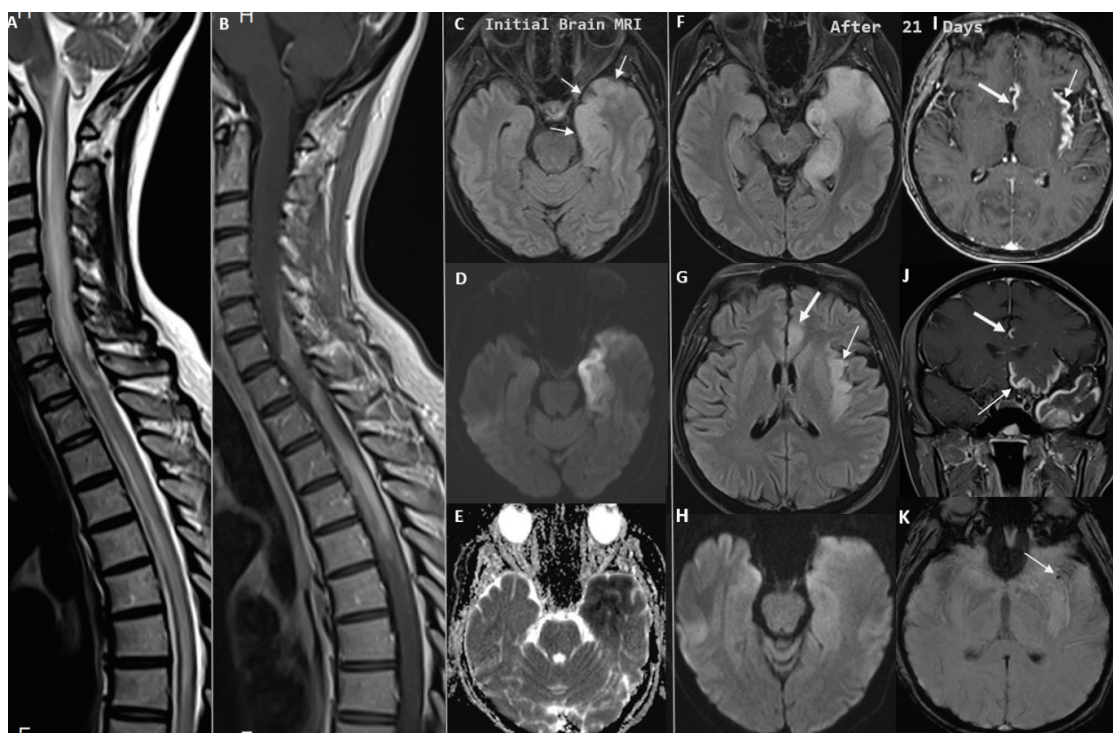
a–k. Sagittal T2W (a) and postcontrast T1W (b) magnetic resonance (MR) images of the spine shows a longitudinally extending from medulla oblongata to 9th thoracic vertebra level, T2-hyperintense (a), heterogeneously contrast-enhancing (b), and expansile intramedullary lesion. Axial FLAIR MR image (c) showing left mesial temporal cortical hyperintensity and swelling (arrows). Diffusion-weighted imaging (DWI)-trace image (d) and ADC map (e) reveals cytotoxic edema in the lesion. Three weeks after initiation of acyclovir therapy, axial FLAIR (f, g) and postcontrast T1W images (i, j) demonstrate an increasing extension of the lesion other limbic structures including the cingulate gyrus (g, i, j, thick arrow) insula (g, i, thin arrow) and basis of the frontal lobe (i, thin arrow) and new-onset gyral contrast enhancement. Diffusion-weighted imaging (DWI)-trace image (h) showing resolution of the cytotoxic edema. Susceptibility-weighted image (k) shows a microhemorrhage in the lesion (arrow).
